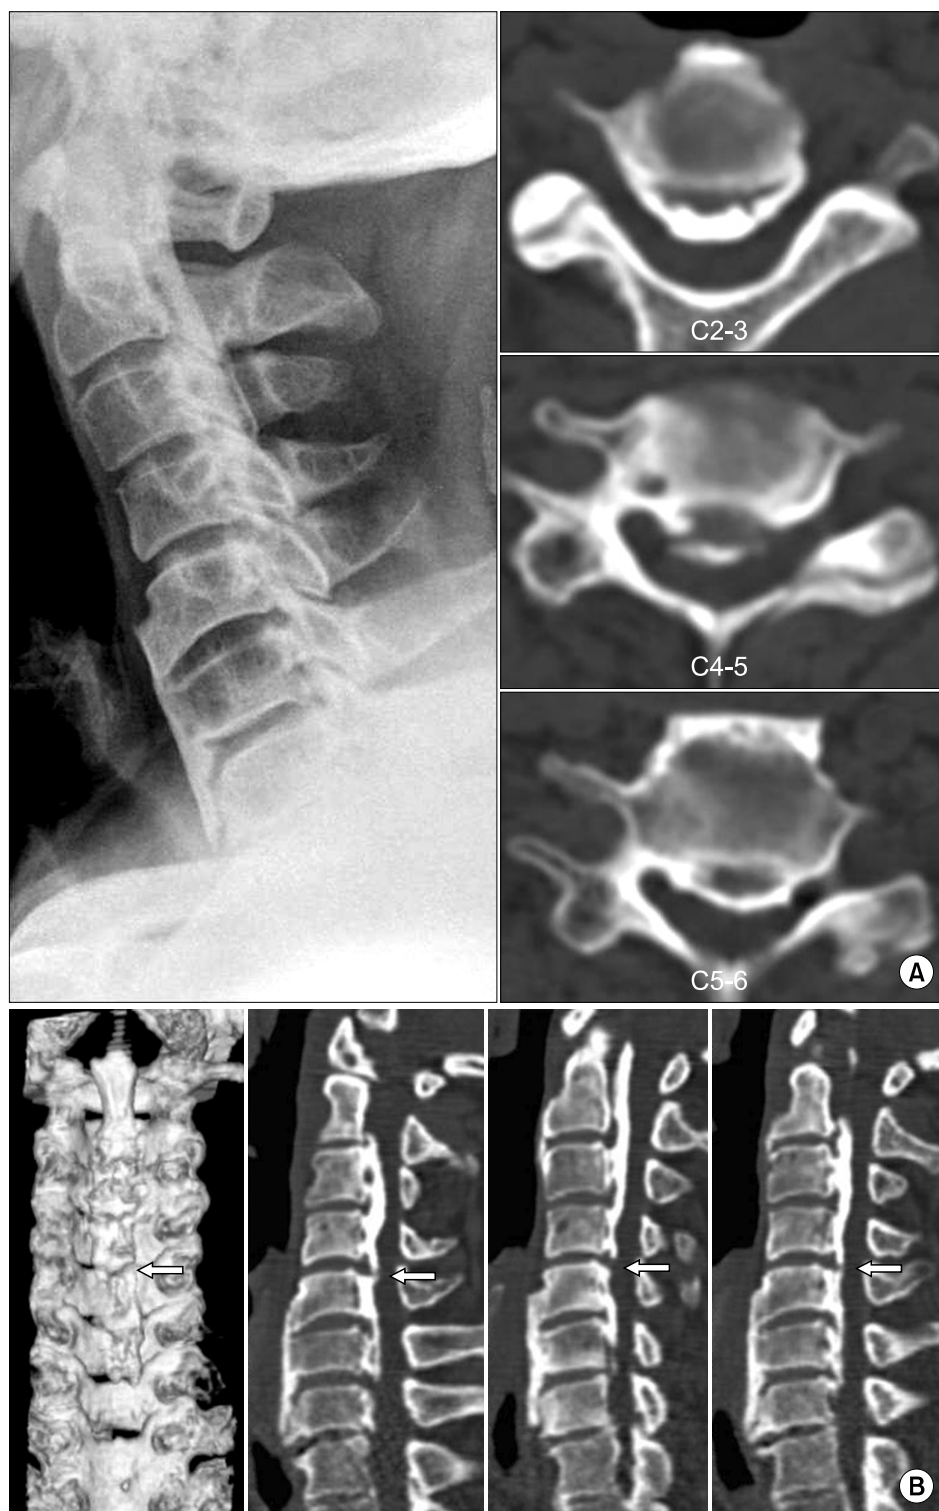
Sixty-one-yr-old male patient presented with the typical clinical symptoms of cervical myelopathy due to ossification of the posterior longitudinal ligament (OPLL). Most reviewers classified this case into the continuous type OPLL extending C1 to C7 using the lateral radiograph in combination with the axial CT images (A). However, the 2-dimensional (2-D) and 3-D CT reconstructed images showed an interrupted OPLL at the C4-C5 disc level (arrow) (B). Most of the reviewers re-classified this case into the mixed type OPLL extending C1 to C7 using the reconstructed CT images.
